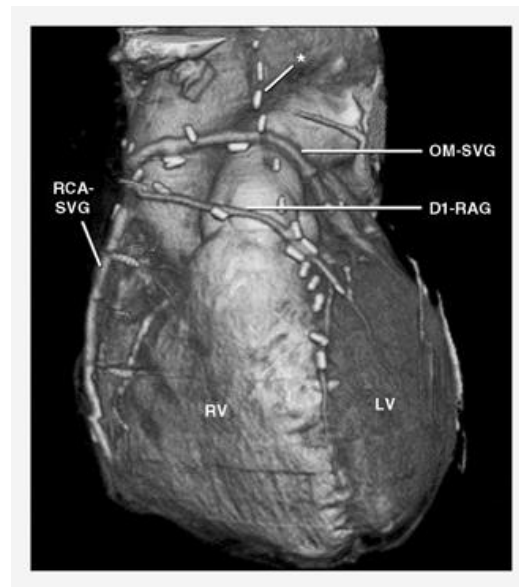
Coronary artery bypass graft computed tomographic angiogram. *Occluded left internal mammary artery graft to the left anterior descending artery. D1-RAG, radial artery graft to first diagonal branch; LV, left ventricle; OM-SVG, saphenous vein graft to obtuse marginal branch; RCA-SVG, saphenous vein graft to right coronary artery; RV, right ventricle. (Quoted from Gerber et al, 2007.)
